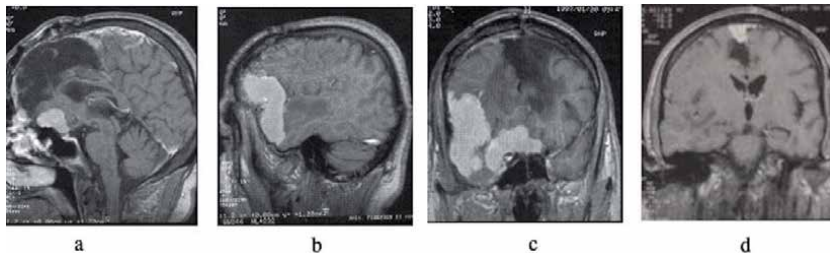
Post-contrast MRI of a 58 years old man with history of previous surgery (5 years before) of gross-total resection of a bilateral meningioma of the anterior third of the falx (WHO grade II). Sagittal (a-b) and coronal (c-d) T1 sequences: distant and diffuse recurrence at the right fronto-temporal bone and suprasellar regions, with no recurrence at the initial tumor site. Reoperation and resection of the recurrent tumor (WHO grade II). Postoperative death for respiratory failure.
